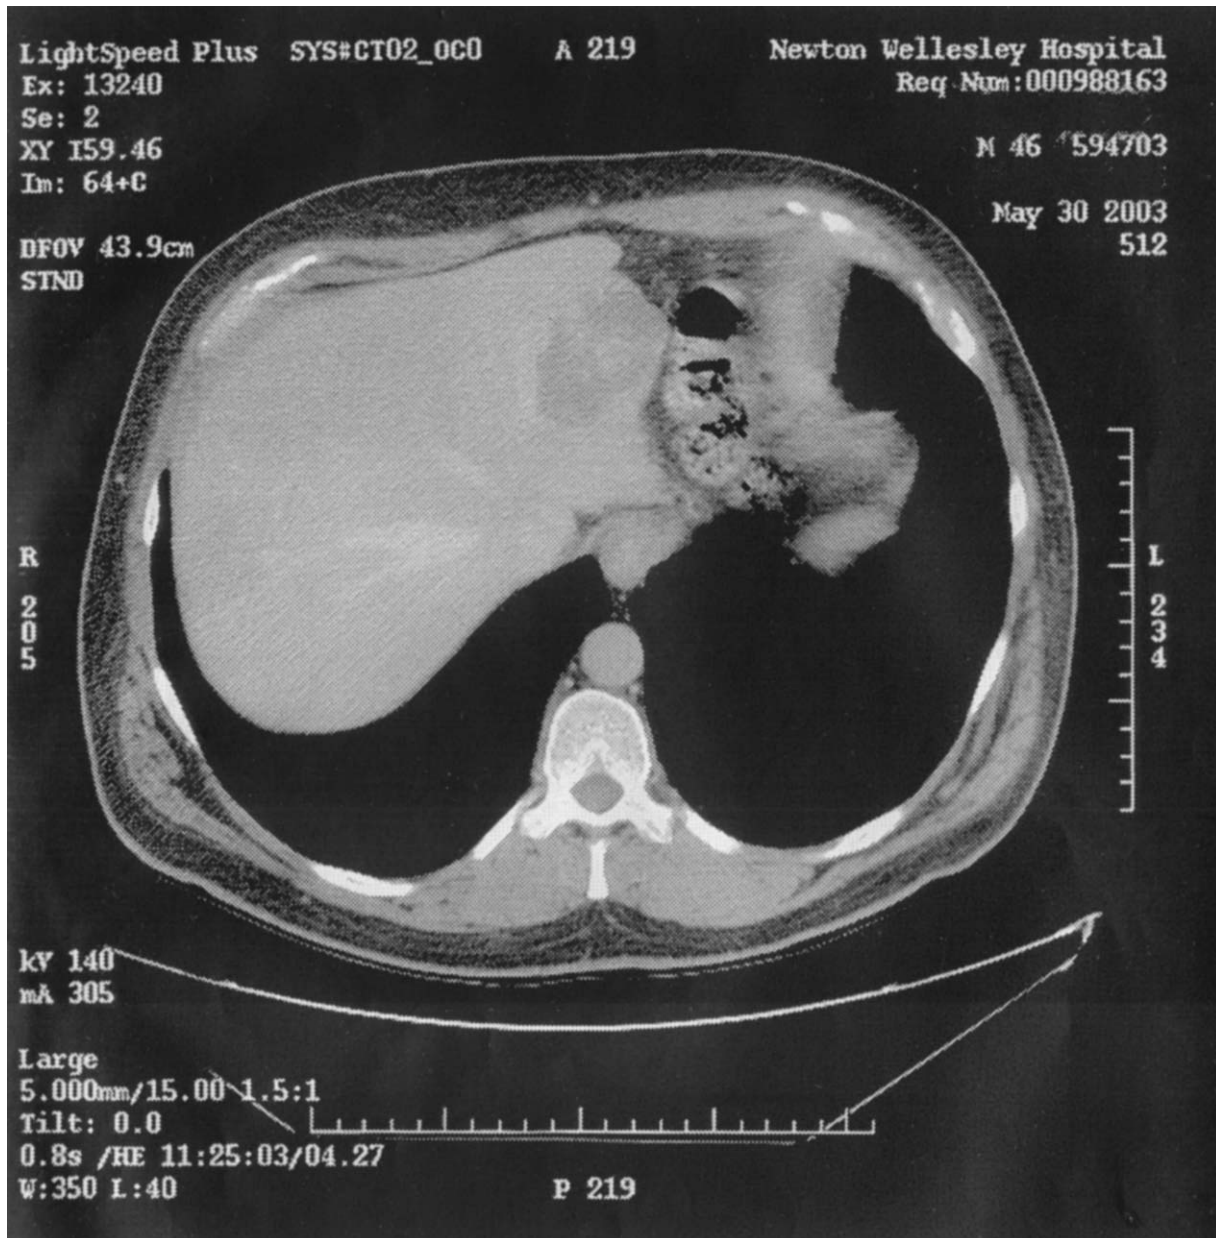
Computed tomography scan showing the lesion in segment 2-3 of the liver, which measured at least 3 cm in diameter.
